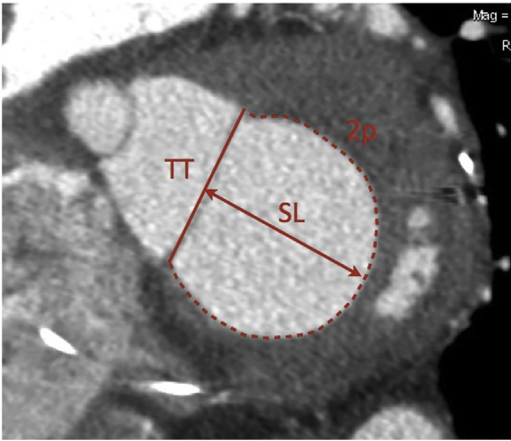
Mitral annulus measurement using multidetector computed tomography. SL, septal-to-lateral distance; TT, trigone-to-trigone distance; 2p, perimeter. (From Faggioni L, Gabelloni M, Accogli S, Angelillis M, Costa G, Spontoni P, et al. Preprocedural planning of transcatheter mitral valve interventions by multidetector CT: What the radiologist needs to know. *Eur J Radiol Open.* 2018;5:131-40.)
